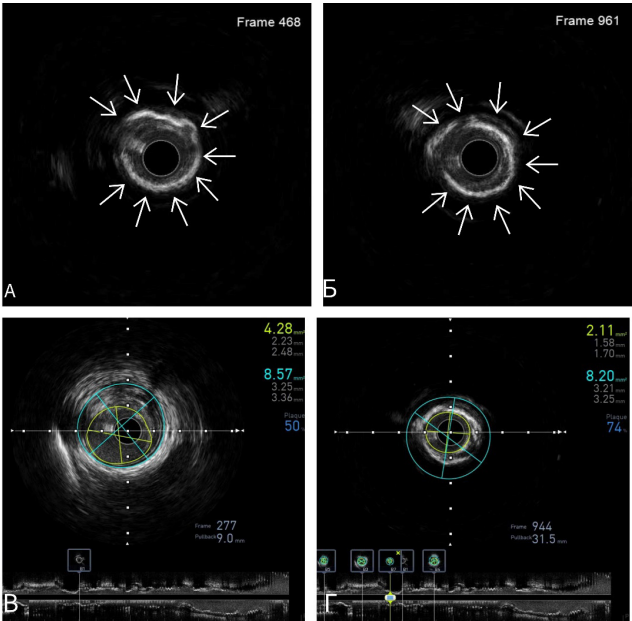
Intravascular ultrasound examination of the LAD. A. Circular calcium in the middle segment. B. Circular calcium in the proximal segment. C-D. Digital indicators of the affected area.
